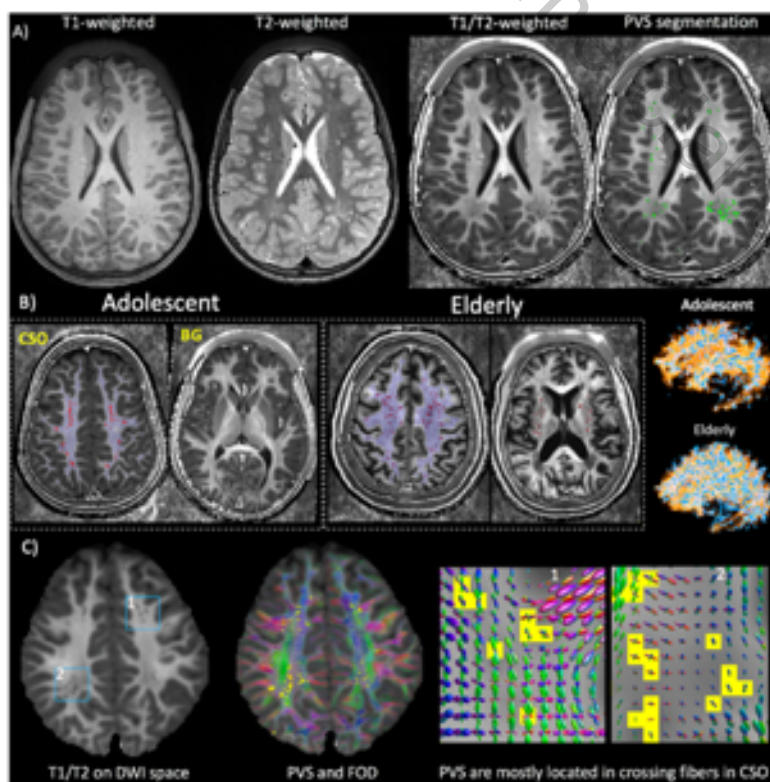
PVS segmentation using A) T1-weighted/T2-weighted ratio images; B) Representative PVS segmentation in CSO and BG of adolescent and elderly brains. C) PVS masks and fiber orientation distribution (FOD) overlaid on T1/T2 images.
